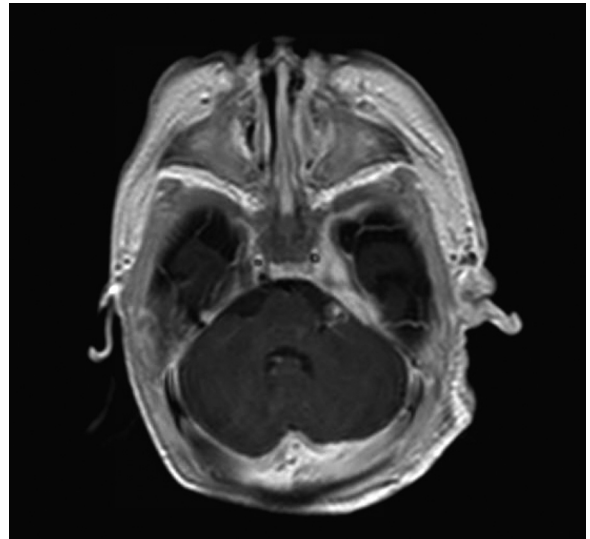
Axial T1 weighted post-gadolinium MRI of the brain demonstrating asymmetry within Meckel's cave secondary to hemangioma involvement.
